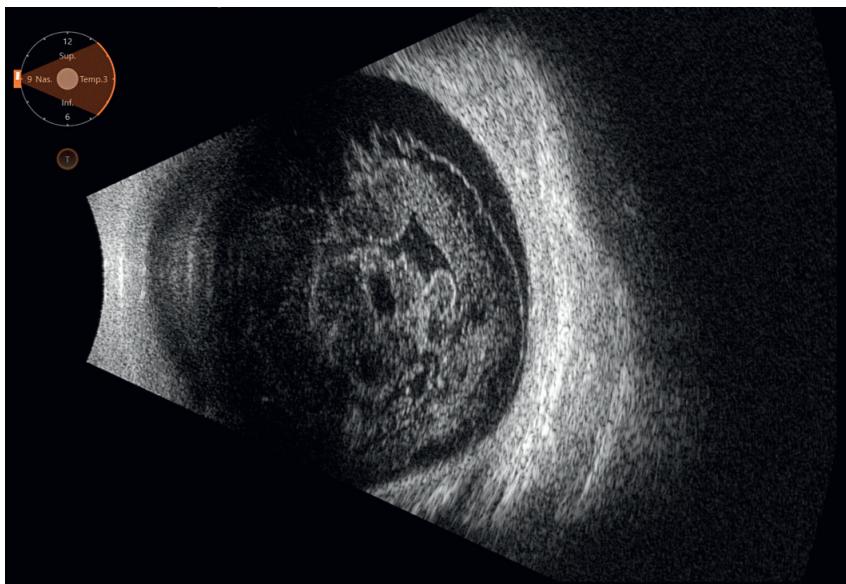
Vitreous hemorrhage with visible lacunas in the ultrasound examination of the eyeball.
